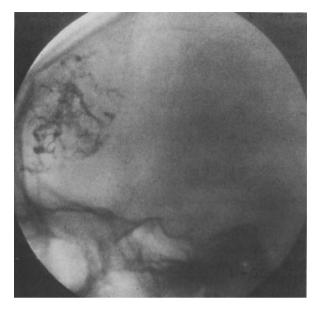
Plain X-ray showing casting of the frontal AVM (lower left)
